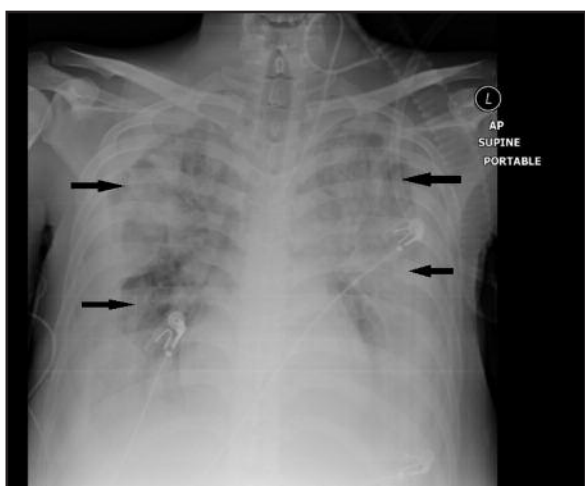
A chest radiograph shows diffused bilateral lung consolidation involving more than three zones (arrow).
